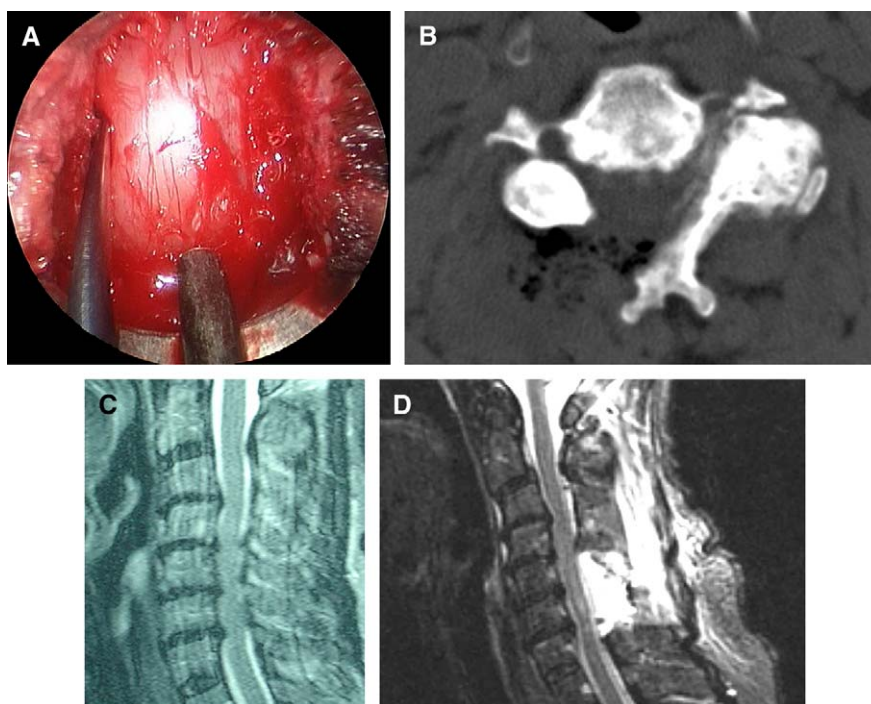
(A) Intraoperative view of decompression. (B) Preoperative sagittal T2-weighted MRI scan. (C) Postoperative sagittal T2-weighted MRI scan. (D) Postoperative axial CT scan.
